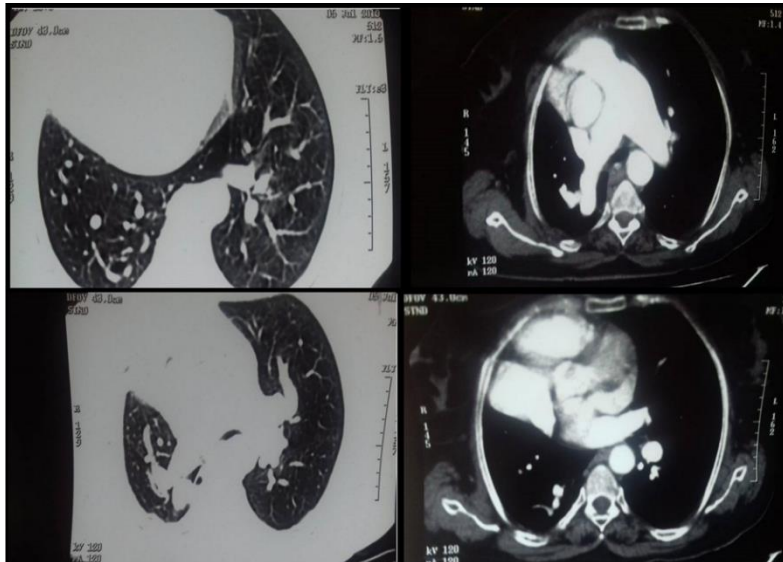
CT angiography: a mediastinal shift to the right, main pulmonary artery dilation with a diameter of 42 mm, a partial abnormal pulmonary venous return (APVR) with connection of the right pulmonary artery to the inferior vena cava, agenesis of the right upper lobe.
